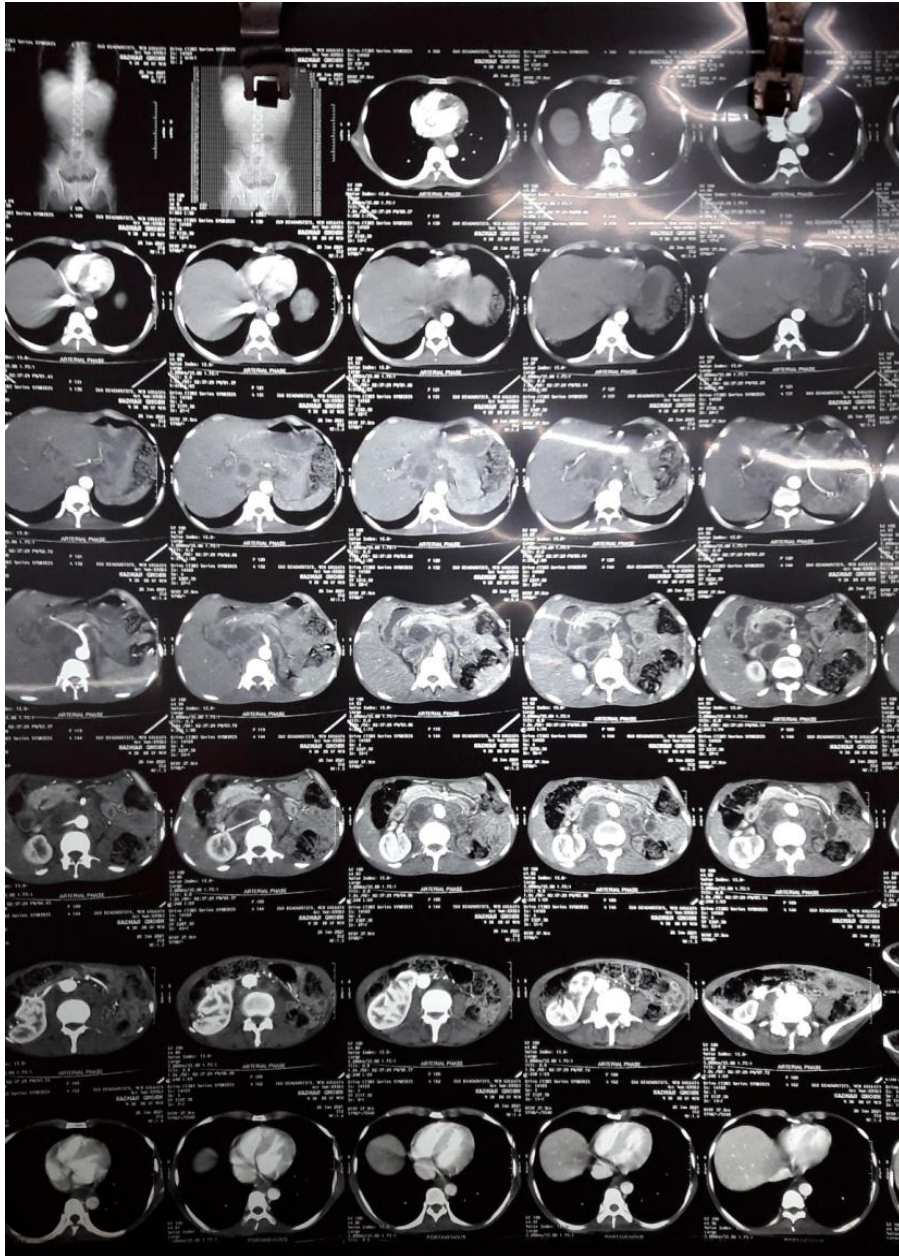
CT abdomen showing multiple enlarged RPLN and ectopic fusion of kidneys on right.
